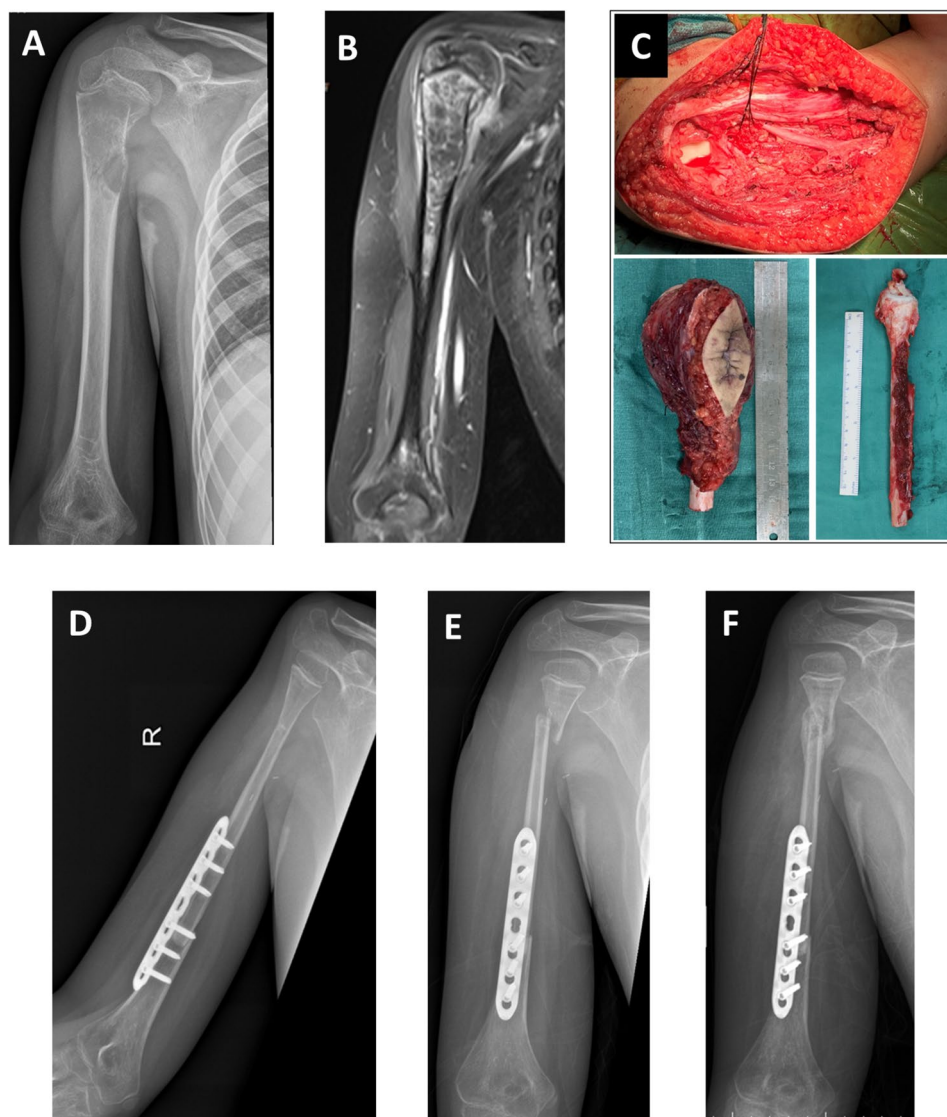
A case of graft fracture. Preoperative X-ray(A), MRI(B), and intraoperative photographs(C) of a 11-year-old male patient diagnosed with osteosarcoma in the right proximal humerus. This patient underwent resection of proximal humerus tumors and subsequent reconstruction using a vascularized fibula graft(D). Four months after surgery, the graft was fractured due to a fall(E). The graft fracture healed successfully after plaster fixation (F). (Case 3 in Table 1)
